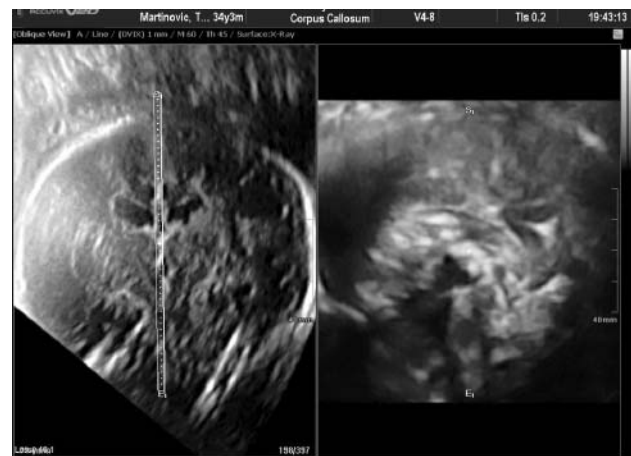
Ultrasound scan of fetal brain.
